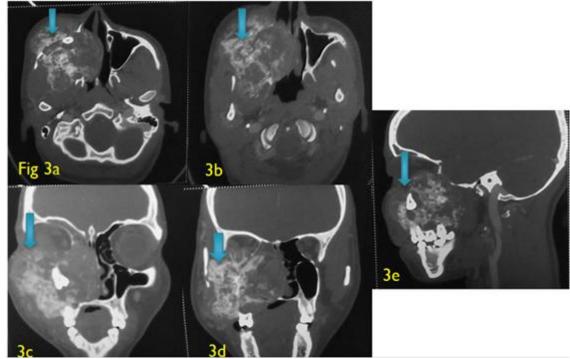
(a –b)(axial), Figure 3c-d (coronal) CT bone window images shows coarse internal calcification. Figure 3e (sagittal) CT bone window image shows non-erupted tooth within the lesion.
